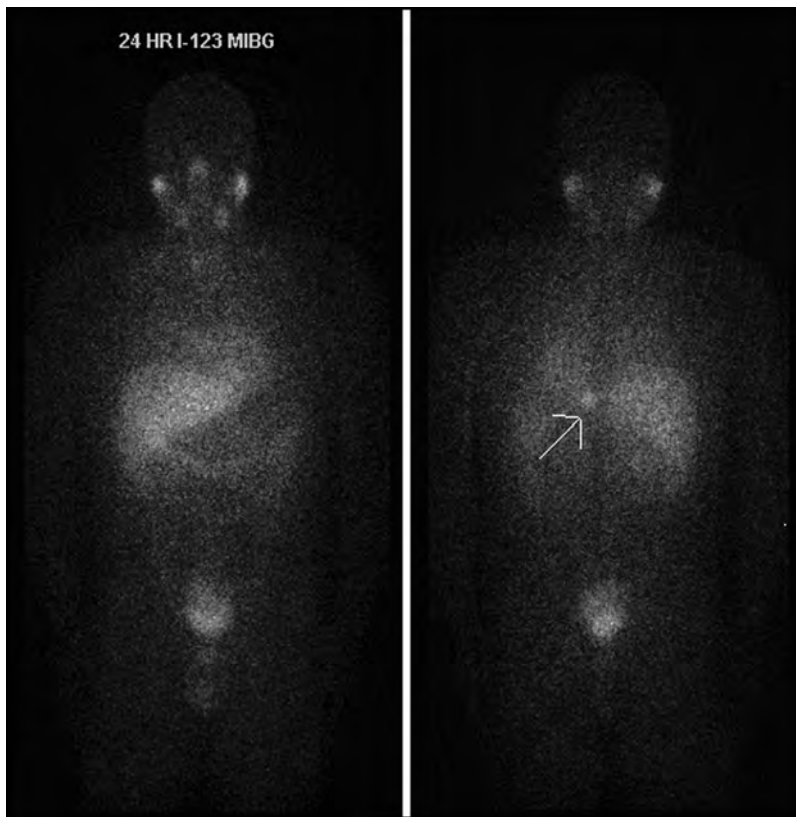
MIBG scan, showing increased paraspinal uptake corresponding to mass on CT.
